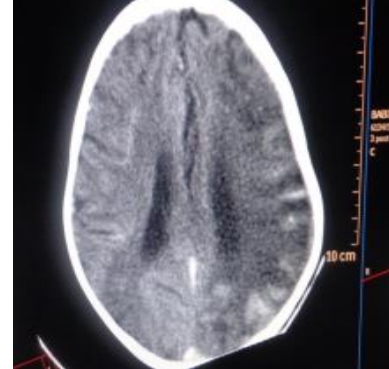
Axial contrasted helical brain CT scan showing a luxuriant enhancing lesion in the left parietal region.
